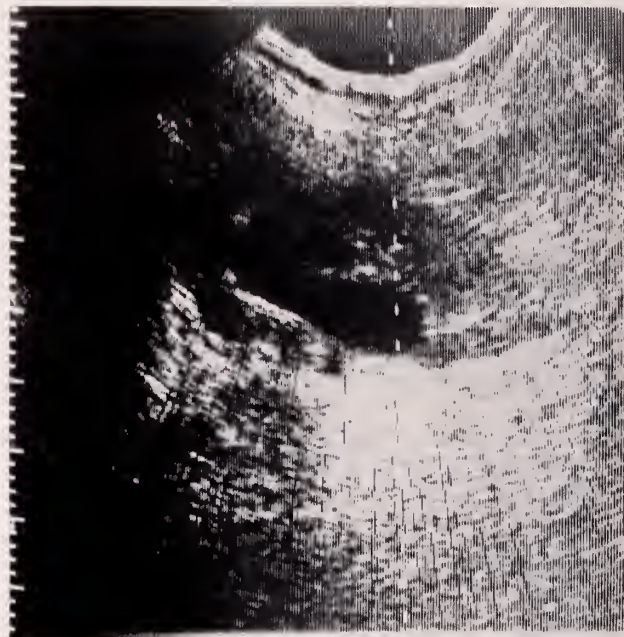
The dilated renal pelvis is localized with ultrasound and needle path was selected.
